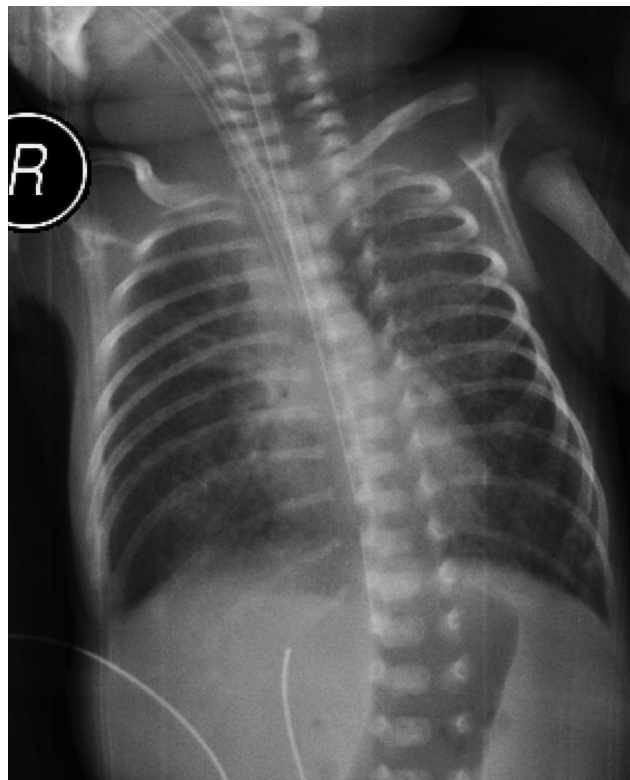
Chest X-ray after 12 hours of N-acetylcysteine instillation. Near-total resolution or expansion of the right lung was observed
